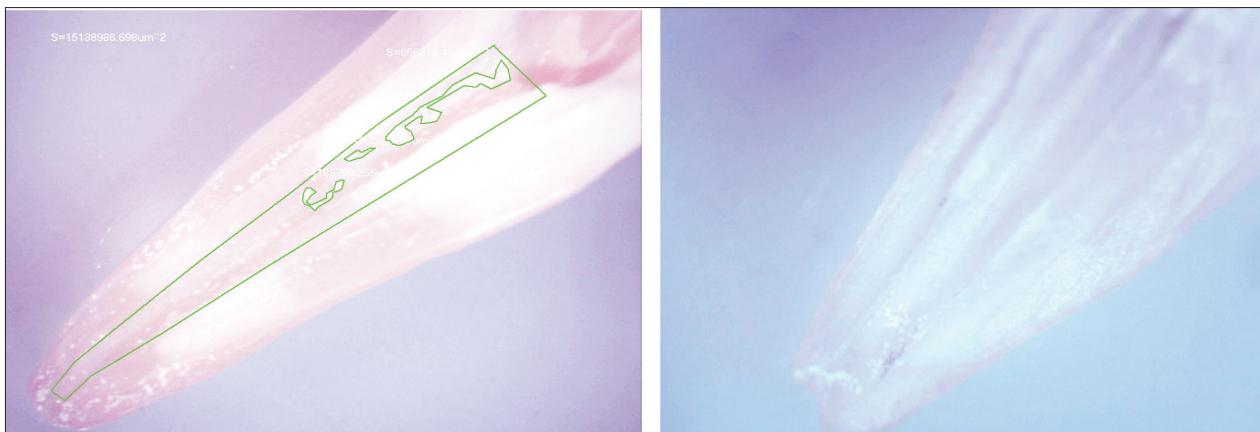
Well-cleaned root canal surface, especially in the apical third, after passive ultrasonic irrigation
